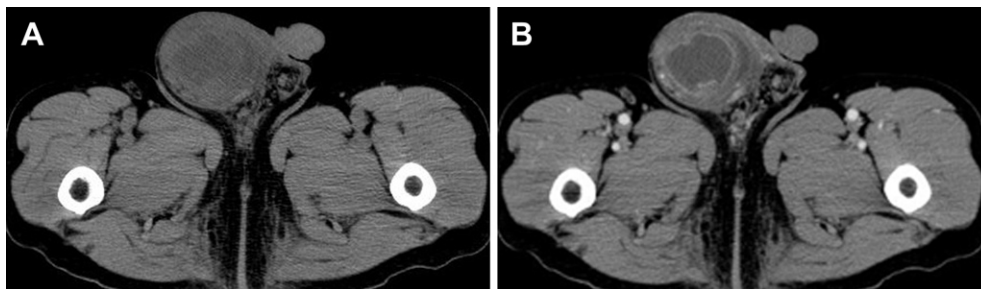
(A) Noncontrast-enhanced and (B) contrast-enhanced axial computed tomography images of the inguinal region reveal marked enlargement of the right scrotum with wall thickening and edematous changes. There is localized fluid collection with rim enhancement within the right scrotum, compatible with an abscess. A small amount of perifocal hydrocele is also present.
